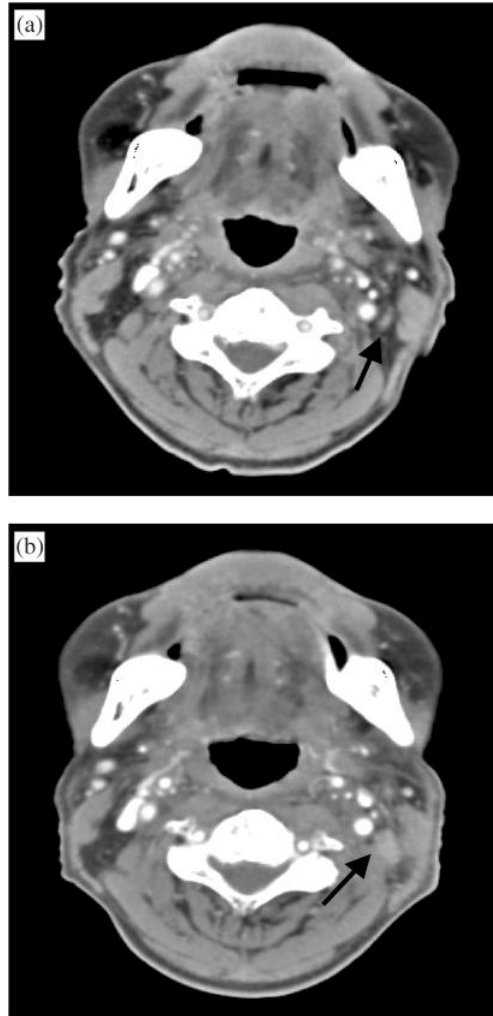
(a) Contrast-enhanced CT shows no significant cervical lymphadenopathy following neck irradiation for nasopharyngeal cancer. Note the innocuous looking lymph node (arrow). (b) Follow-up (1 year later) shows definite enlargement of cervical node (arrow). The node was not palpable because of its size, its location beneath the sternocleidomastoid muscle and the irradiation-induced neck induration.
